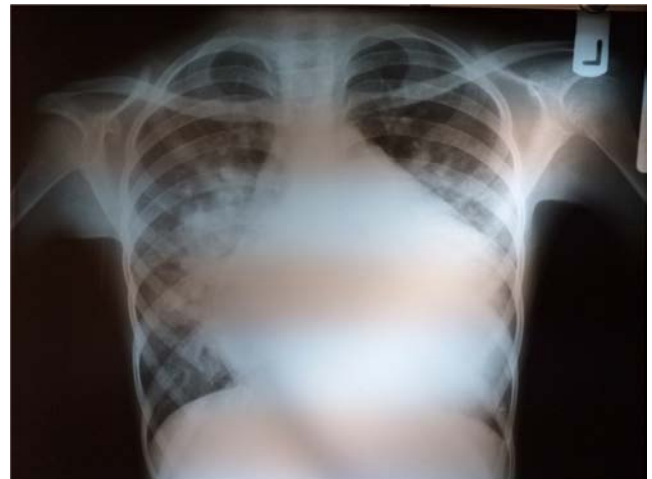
Chest X-ray showing cardiomegaly and pulmonary plethora.
